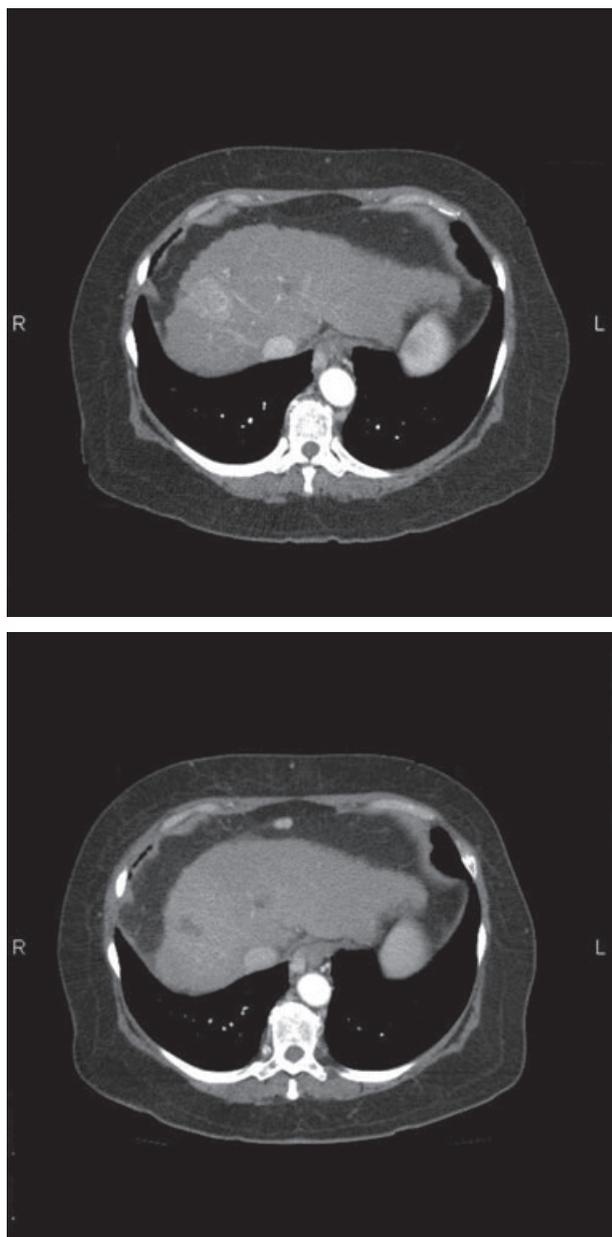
CT showing radiological response, with a zone of necrosis and no uptake of contrast on arterial phase.
